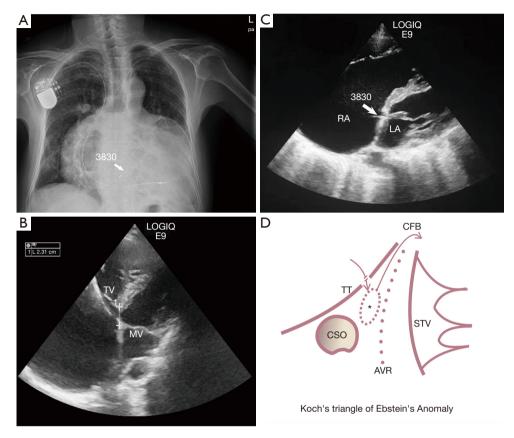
Lead location. (A) Chest radiograph recorded the leads and presented the large heart; (B) echocardiography showed the distance between the attachment points of MV and TV; (C) the tip of the 3830 lead was detected at the atrial side near the attachment point of MV; (D) imitate the Koch's triangle of the patient. Asterisk* means the pacing site. TT, Tendon of Todaro; STV, septal tricuspid valve; CSO, coronary sinus ostium; CFB, central fibrous body.
